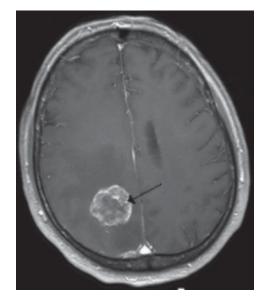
CT scan of brain showing right hemispheric intracerebral tumour
